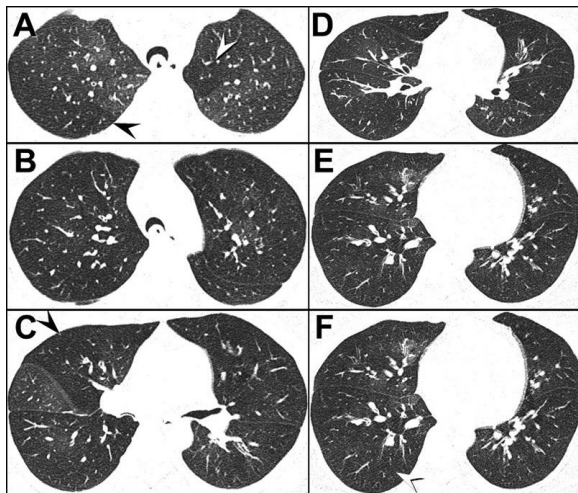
Axial unenhanced post-expiratory HRCT images through the upper (A and B), mid (C and D) and lower (E and F) lungs. Click [here](#) to view Figure 10 in a separate, enlarged window. Click [here](#) to view a video of Figure 10.
